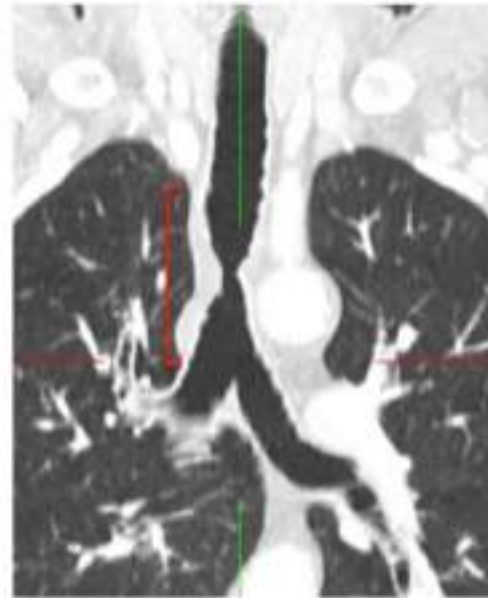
Computed tomography of a 70 year-old with adenoid cystic carcinoma of the trachea. Note the longitudinal tumor growth pattern (red bracket). 1. Grillo HC. Surgery of the trachea and bronchi. Hamilton, Ont.; Lewiston, NY: BC Decker; 2004. 2. Mallick S, Benson R, Giridhar P, Rajan Singh A, Rath GK. Demography, patterns of care and survival outcomes in patients with malignant tumors of trachea: A systematic review and individual patient data analysis of 733 patients. *Lung Cancer*. 2019;132:87-93. 3. Wright CD, Grillo HC, Wain JC, et al. Anastomotic complications after tracheal resection: prognostic factors and management. *The Journal of thoracic and cardiovascular surgery*. 2004;128(5):731-739. 4. Auchincloss HG, Wright CD. Complications after tracheal resection and reconstruction: prevention and treatment. *J Thorac Dis*. 2016;8(Suppl 2):S160-167. 5. Urdaneta AI, Yu JB, Wilson LD. Population based cancer registry analysis of primary tracheal carcinoma. *Am J Clin Oncol*. 2011;34(1):32-37.
